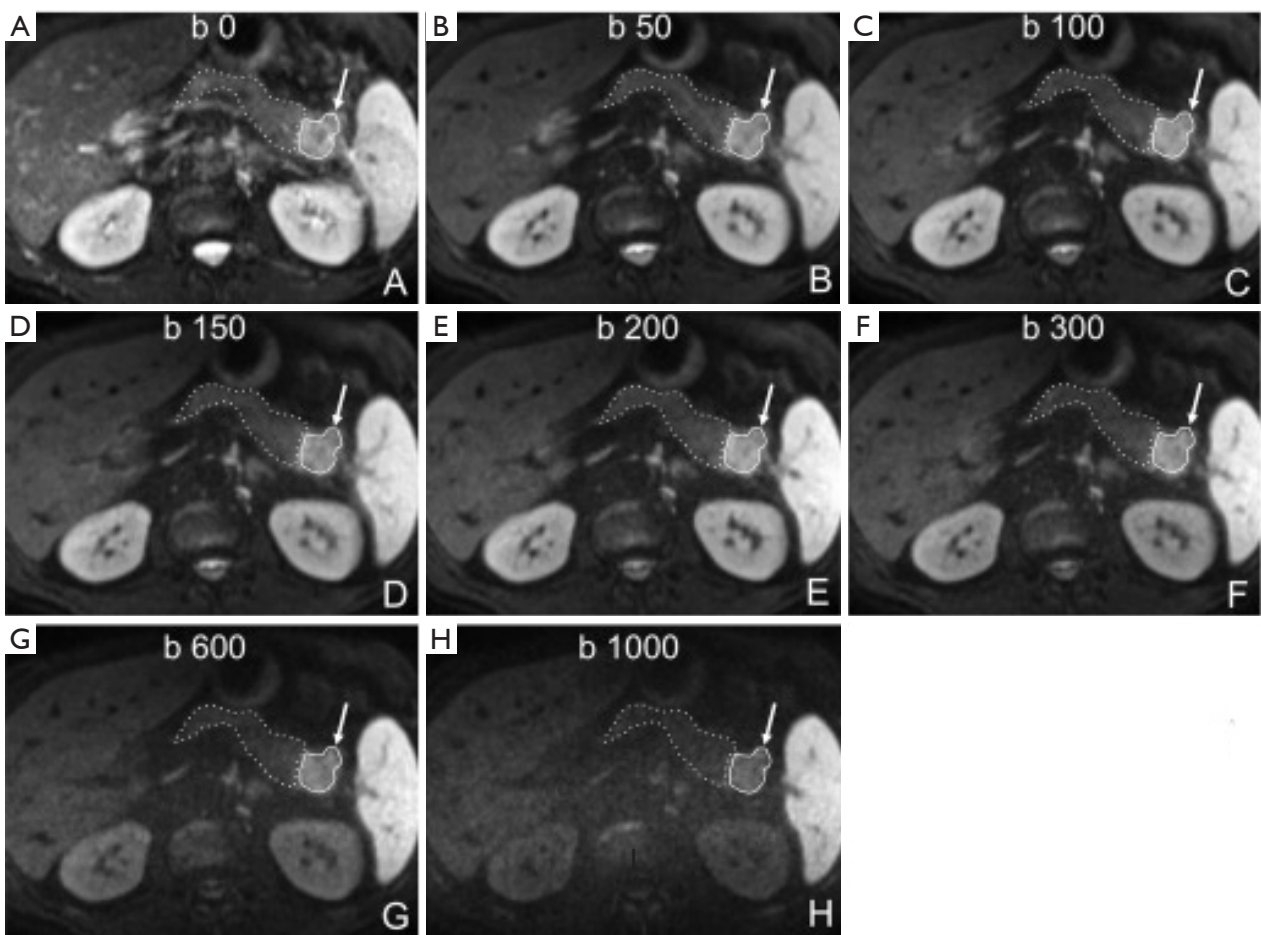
Pancreas ductal adenocarcinoma is associated with increased T2 time and decreased ADC. A 65-year-old male patient with a ductal adenocarcinoma at the pancreatic tail. (A-H) Axial DWI images with increasing b -values from 0 to 1,000 s/mm^2 . Restricted diffusion of the tumour (arrow, continuous line) compared to the adjacent parenchyma (dashed line). The tumor shows relative high signal as compared to adjacent pancreas parenchyma on $b=0$ image (when diffusion gradient was not on), suggesting its increased T2 time. The signal change of the pancreas is close to that of the liver, while the tumor shows signal more closer to that of the spleen. At 3T, the T2 time is estimated to be 34, 43, and 61 ms for liver, pancreas, and spleen, respectively (4). Reproduced from Kartalis *et al.* (18). ADC, apparent diffusion coefficient; DWI, diffusion-weighted imaging; ms, millisecond.
